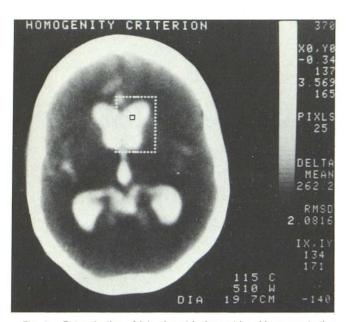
Determination of lateral ventricular metrizamide concentration using minimum variance computer program. Rectangular region of interest (dotted lines) is superimposed on CT image and encompasses part of right lateral ventricle. *X* and *Y* coordinates at center of region of interest (*XO*, *YO*) are at upper right. 5 × 5 pixel cursor (area 25 pixels) systematically surveys region of interest, and 25 pixel square with the smallest variance (root mean square 2.0816) is automatically selected as defining most'homogeneous region within metrizamide-filled ventricular contour (threshold $150 < \bar{X} < 350$ Delta units). Mean CT number of square is 262.2 Delta units. 25 pixel square is outlined in black on image; location of square is specified by coordinates *IX*, *IY*.
